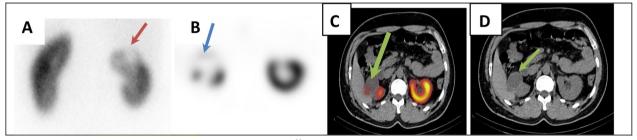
A 43-year-old, male patient, presented with right loin pain. A ^{99m}Tc-DMSA planar image (posterior view) demonstrating defect at the upper outer aspect of the right kidney (red arrow), B axial SPECT image revealed right cortical defects (blue arrow), C the corresponding fused SPECT/CT and D the CT images shows that the defect is corresponding to simple cortical cyst (yellow arrows)
